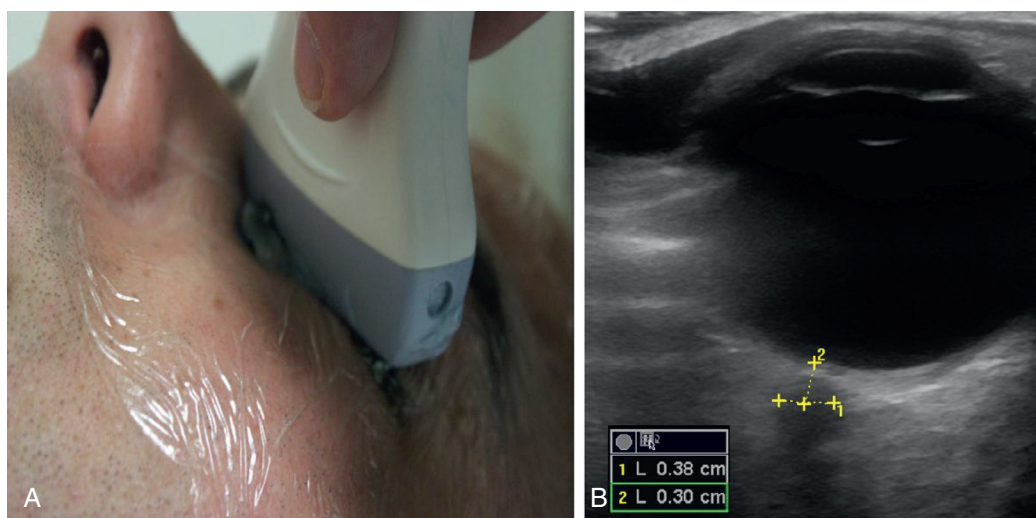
■ Ultrasound of optic nerve sheath diameter. A, Probe (linear) position. B, Ultrasound image.
